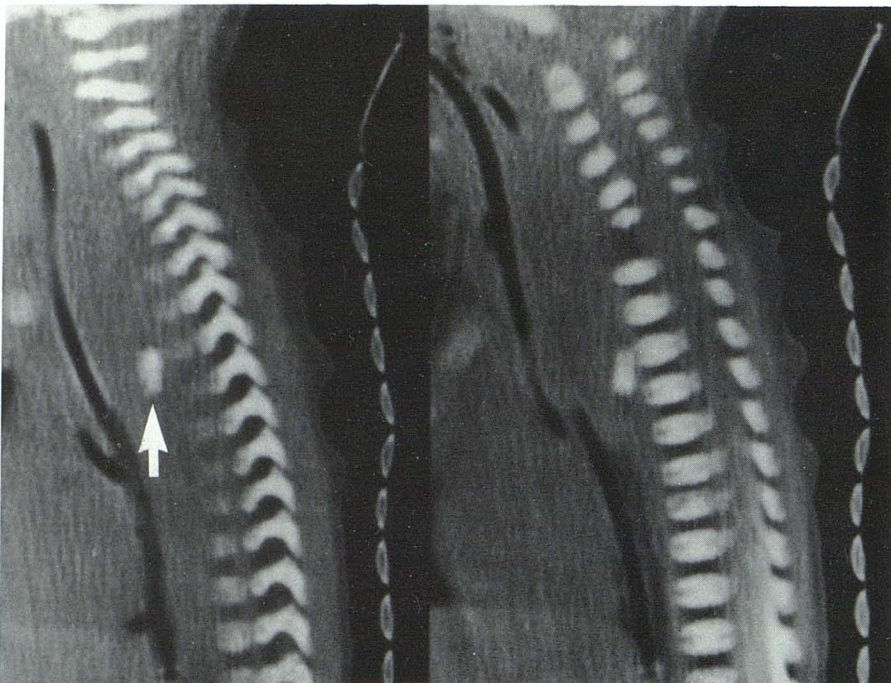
Case 6. Spinal osteomyelitis and posterior mediastinal abscess. Postmetrizamide direct sagittal CT scans off-midline (*left*) and midline (*right*). Large retrotracheal and esophageal abscess displacing these structures forward. Body of C7 (*arrow*) has floated free in pus and lies anterior to T3. Partial destruction of C6. Whole process is thought to have started as osteomyelitis of these vertebral bodies.
